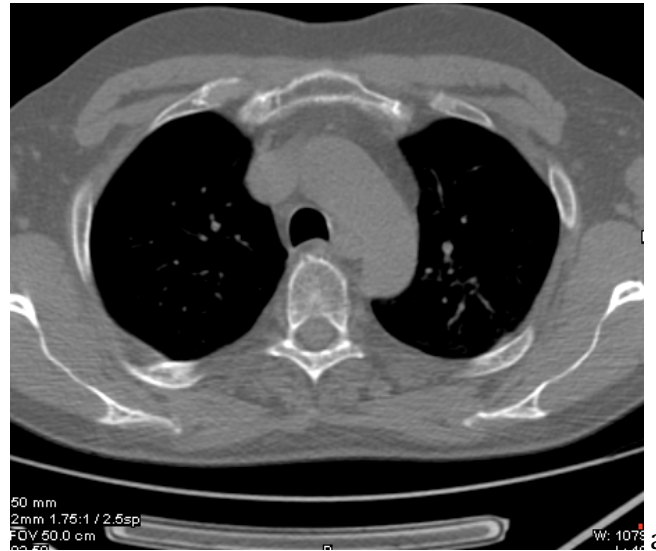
a, b On CT, there is no evidence of sclerotic, lysis, pedicular destruction, or pre- or paravertebral soft tissue abnormality to indicate metastatic disease. b Axial PET/CT and low-dose CT demonstrate an intensely avid lesion at the upper thoracic vertebra, which is in keeping with metastatic disease. In addition, there is an isodense metastatic deposit involving the left 4th rib.
